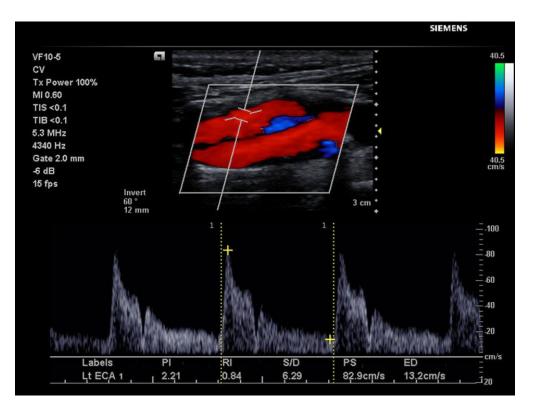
Doppler Ultrasound Imaging.
